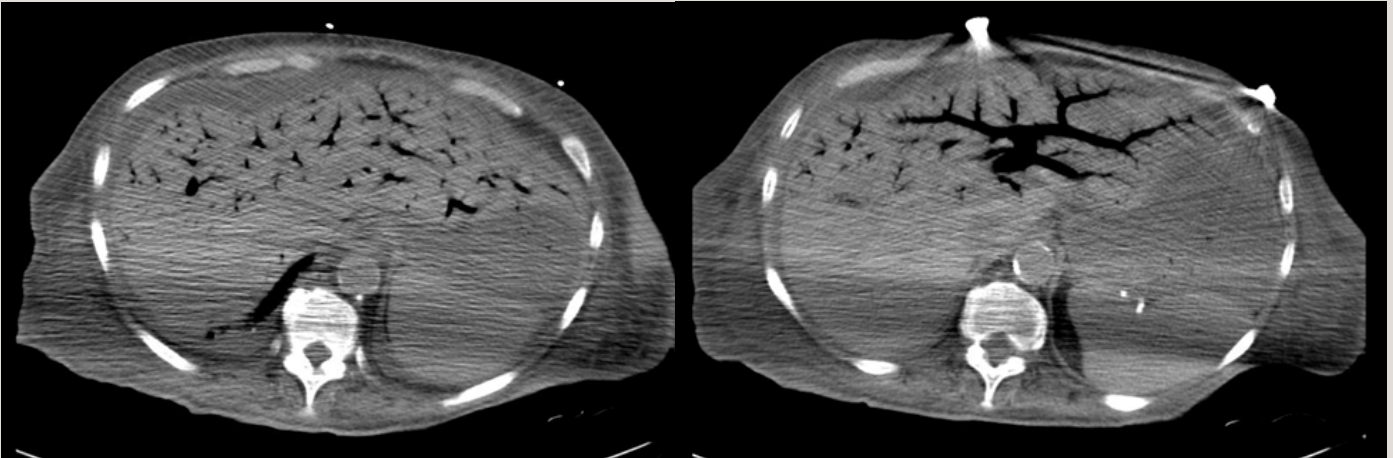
CT scans showing extensive gas within the hepatic portal venous system.
